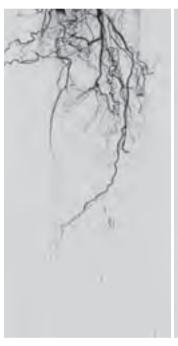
CTA before treatment.
